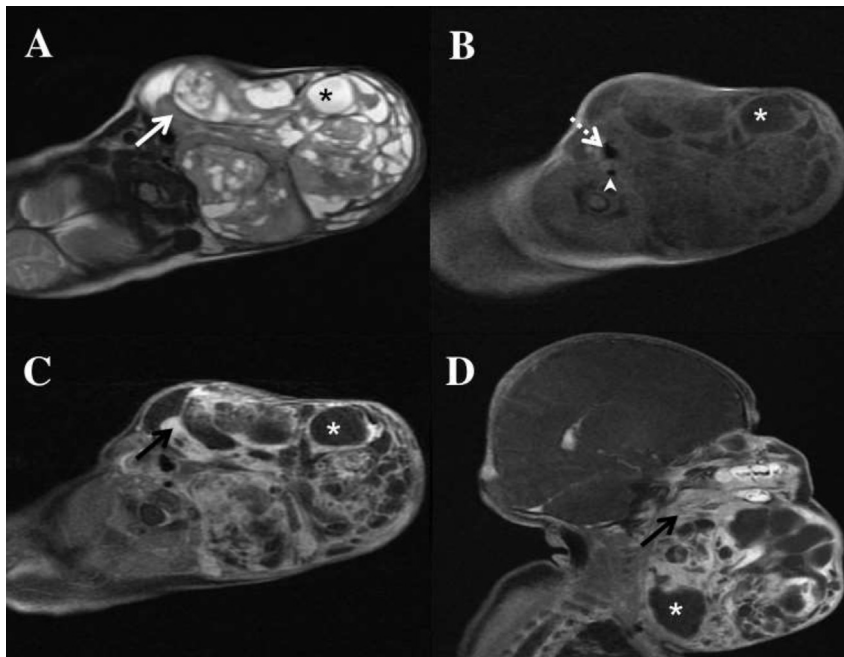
Axial T2 (A), axial T1 pre (B) and post contrast (C), and sagittal T1 post contrast (D) MRI images demonstrate large well-defined multi-lobulated complex neck mass with significant mass effect. The solid component (arrows) shows intermediate T2 and T1 signal intensity with avid heterogeneous enhancement while the cystic component (asterisks) shows high T2 and low T1 signal intensity with no enhancement. Oesophagus (arrowhead) and airway (dashed arrow) are displaced.
